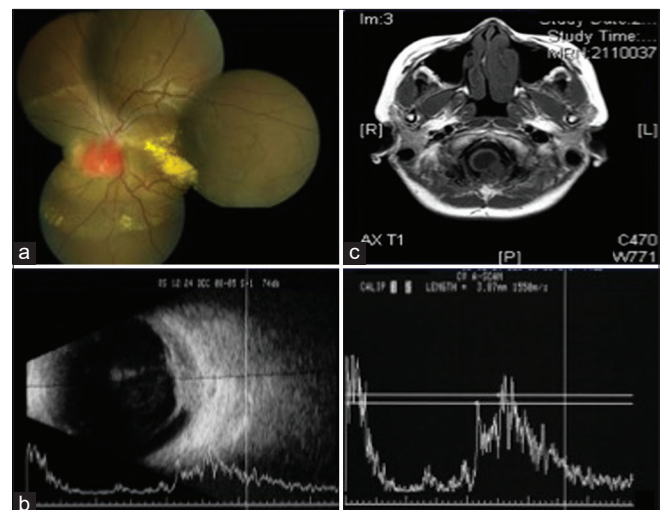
(a) Fundus photo of large hemangioblastoma of the left optic nerve with submacular exudates and subretinal fluid. (b) Ocular ultrasound A and B scan showed medium to high intensity elevated mass. (c) Axial T1-weighted MRI image showed low density cystic lesion with a posterior peripheral soft tissue density that enhances homogeneously with IV contrast, likely a hemangioblastoma of the brain stem
